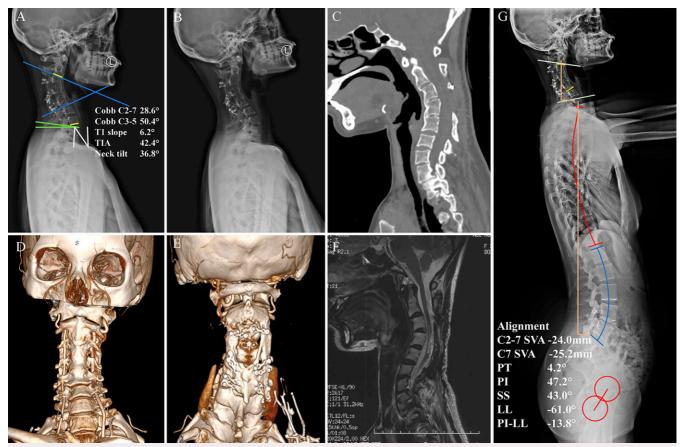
Preoperative assessment of case 2. A: Lateral cervical spine radiograph reveals severe local cervical kyphosis angle (50.4°) with an apex centered over C3–4. B: Radiographs in flexion show no reduction of the kyphosis deformity. C: Sagittal CT reconstruction reveals the incomplete interbody fusion between C2 and C5. D and E: CT three-dimensional reconstruction shows the fixed nature of the deformity with circumferential ankylosis between C2 and C5. F: Sagittal MRI reveals draping of the spinal cord over the posterior aspect of the vertebral bodies. G: Whole-spine plain radiograph shows the translation of the cervical spine in the sagittal plane. TIA = thoracic inlet angle; PT = pelvic tilt; PI = pelvic incidence; SS = sacral slope; LL = lumbar lordosis.
